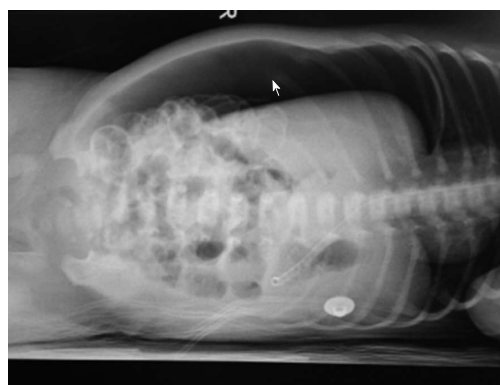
Neonate's radiograph on the 8th d after birth revealed massive free gas in the right part of the abdomen on the liver and intestine.
